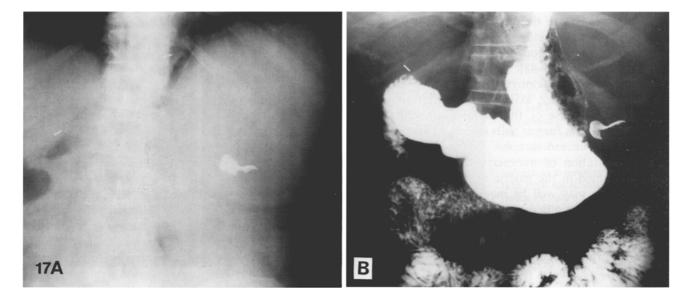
This patient experienced food sticking in lower chest following vagotomy and X-ray studies revealed long smooth narrowing of lower esophagus with partial obstruction. Symptoms abated in several months and the appearance of the lower esophagus returned to normal
